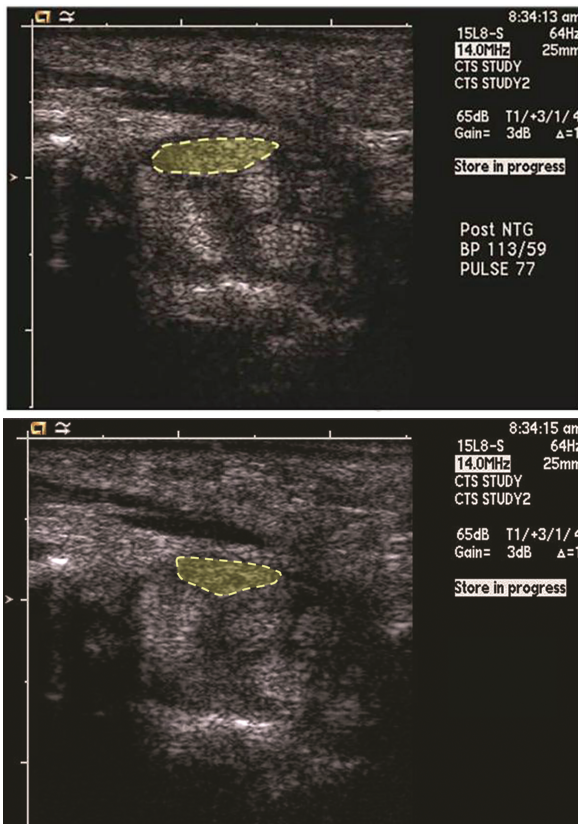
The median nerve at the carpal tunnel in a patient with CTS. At the start (first image) of wrist maximal flexion with fingers extended, the enlarged median nerve (dashed ellipse) was located between the flexor retinaculum and flexor tendons on ultrasound scans in the transverse plane. At the end (last image) of the movement the median nerve (dashed ellipse) was still located between the flexor retinaculum and flexor tendons and had moved only slightly towards the ulnar side of the carpal tunnel.
